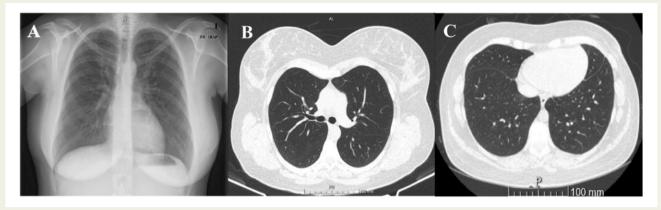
Figure I Chest imaging. (A) Normal chest radiograph. (B and C) Normal high-resolution computed tomography.
